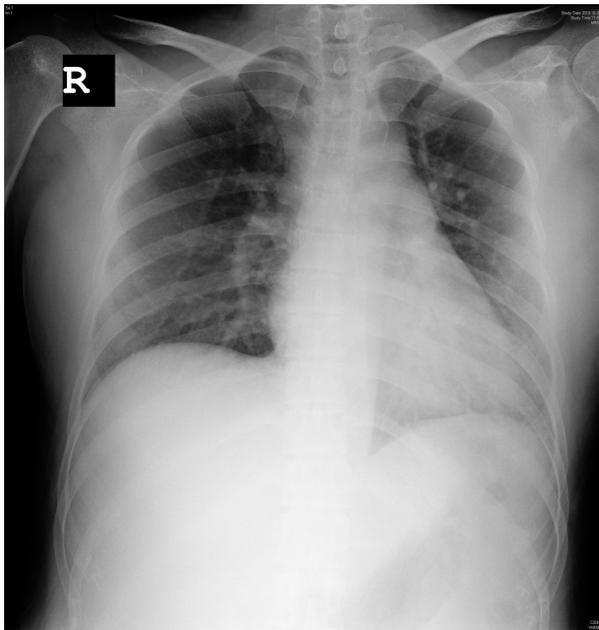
Chest AP X-ray showed pleural effusion and mild cardiomegaly.
